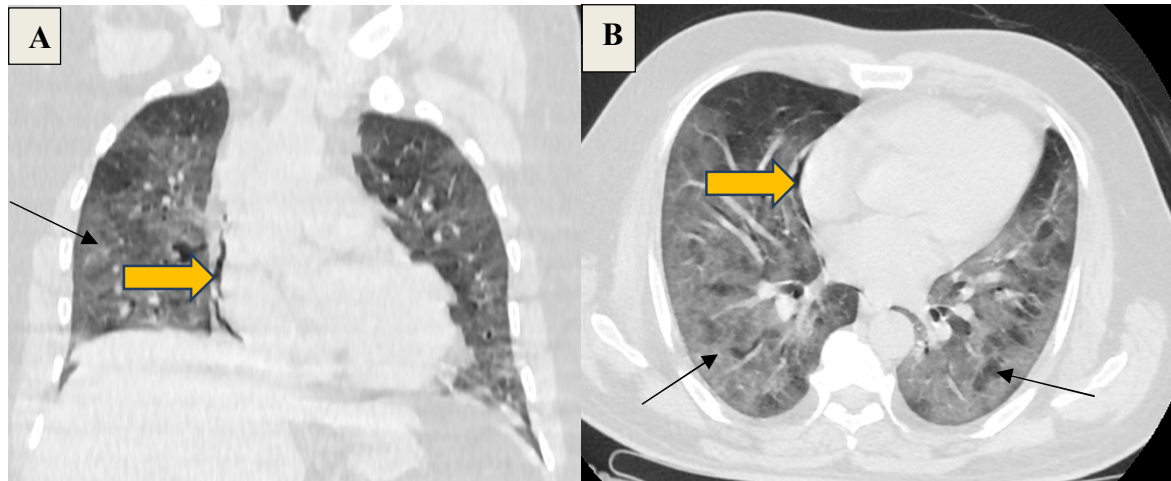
A&B) a 41 year old male CT Chest shows diffuse ground glassing(black arrow) in bilateral lung fields and thin rim of pneumomediastinum(orange arrow) seen in the lower right mediastinum adjacent to the right heart border and diffuse ground glass opacities in bilateral lung fields categorized as CORADS-6 with CT severity score of 21/25(severe)
